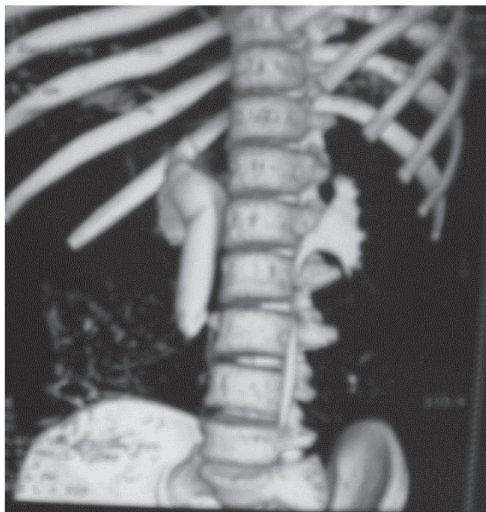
Abdominal computed tomography (CT) reveals right-sided hydronephrosis and dilatation of the proximal ureter.
